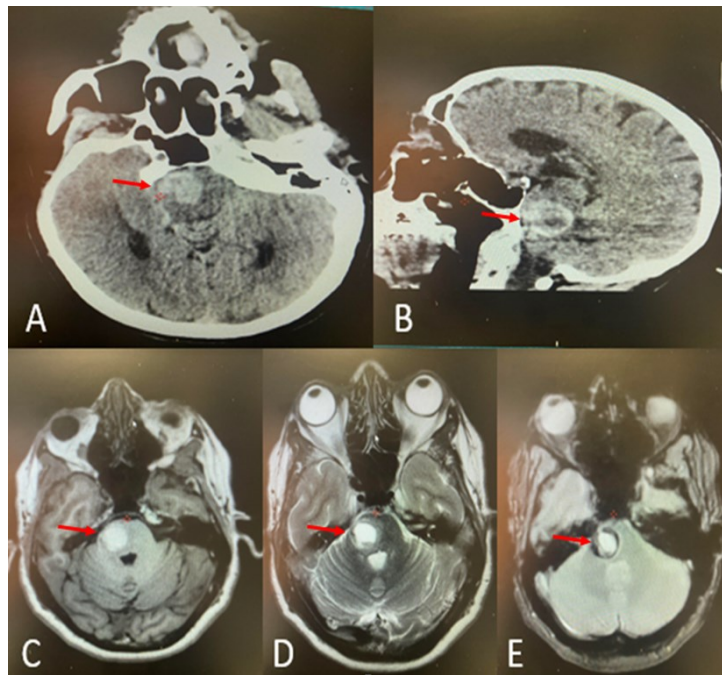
Image findings; (A) Axial cerebral CT-scan and (B) sagittal showing a right pons cavernous hematoma; (C) MRI T1-weighted depicted a hematoma on cavernoma; (D) IRM T2-weighted and (E) SWAN showed a right pons cavernoma (Zabramski I et al).
